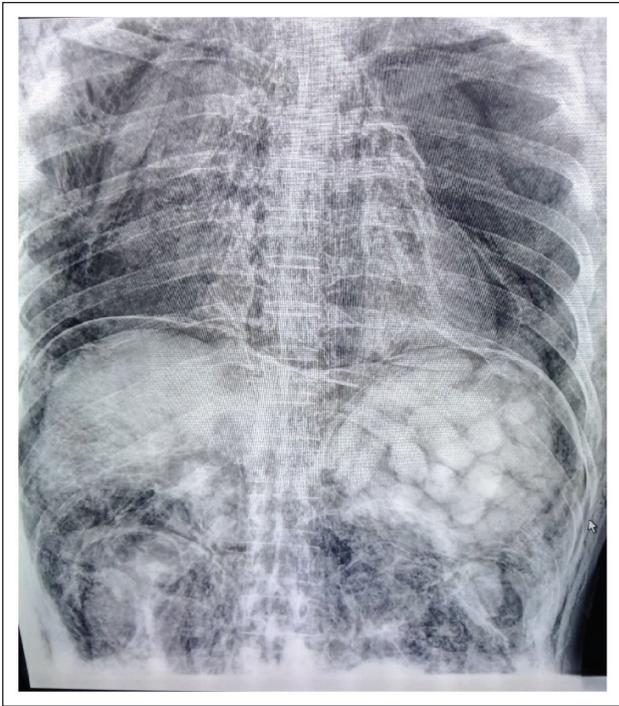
X-ray Abdomen Showing Multiple Egg-shaped Packages.
